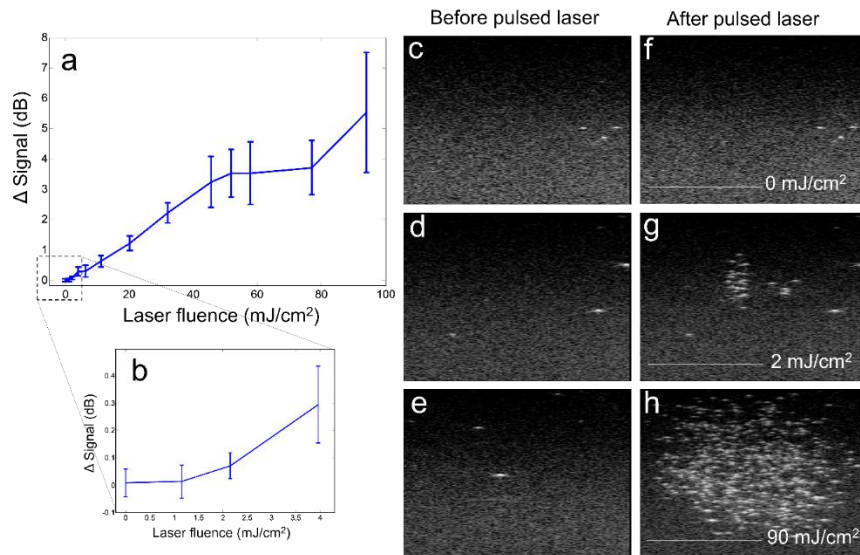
(a) Ultrasound signal difference as a function of laser fluence. (b) Ultrasound signal difference at low laser fluences, demonstrating the fluence at which measurable vaporization is detected. (c-e) Droplet-laden polyacrylamide construct before pulsed laser irradiation. (f-h) Construct after irradiation at various fluences, showing droplet vaporization. Images displayed on a 50 dB scale. Scale bar = 5 mm.
